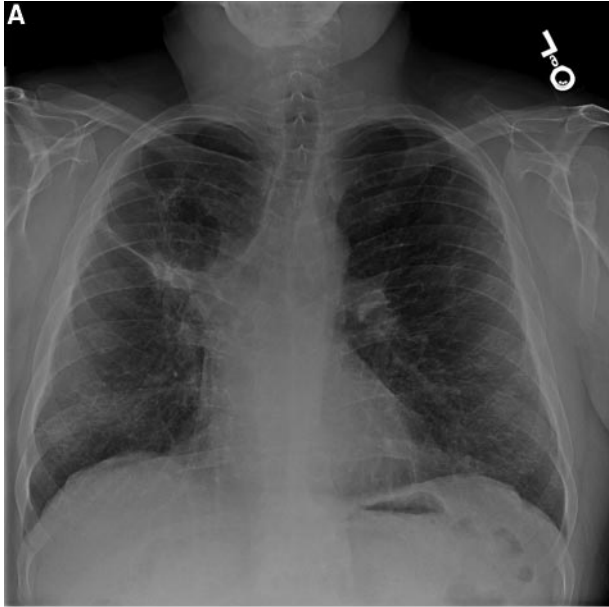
Top, A:* chest radiograph of a patient with WG. *Bottom, B:* CT scan further delineating the right upper lobe lesion that is radiographically indistinguishable from malignancy or abscess.
